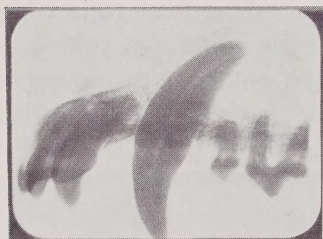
RADIOGRAPH PRINT
